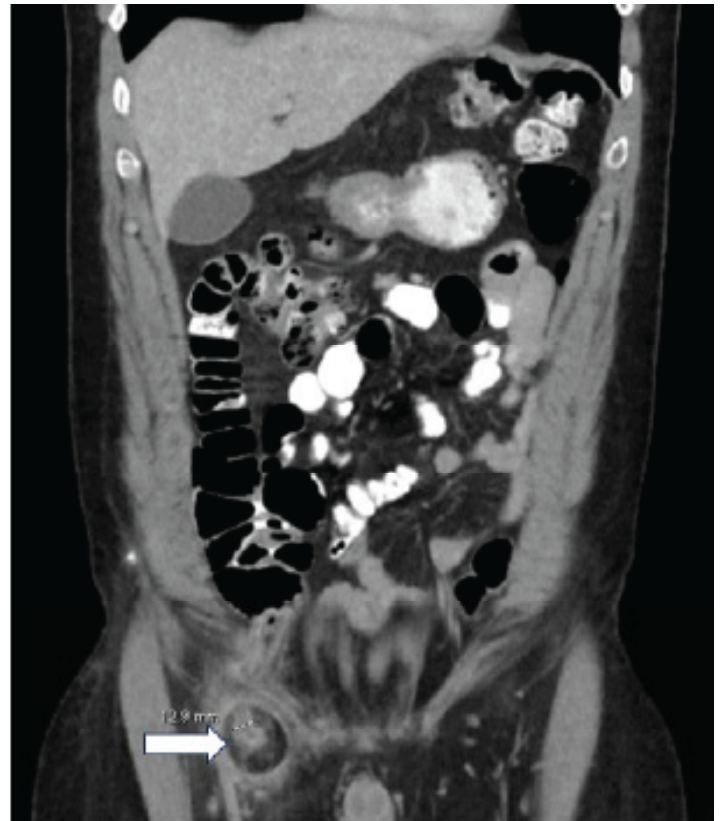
Coronal view of a computed tomography of the abdomen pelvis with a dilated appendix at 12.9 millimeters (arrow) and inflammatory changes around the appendix and hernia.
